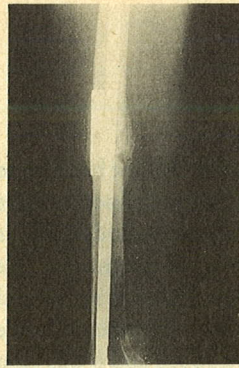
Post-operative radiograph of the same case after removal of the plate and revision of fixation using an intramedullary nail and supplemented with derotation plate and autogenous cancellous graft.
